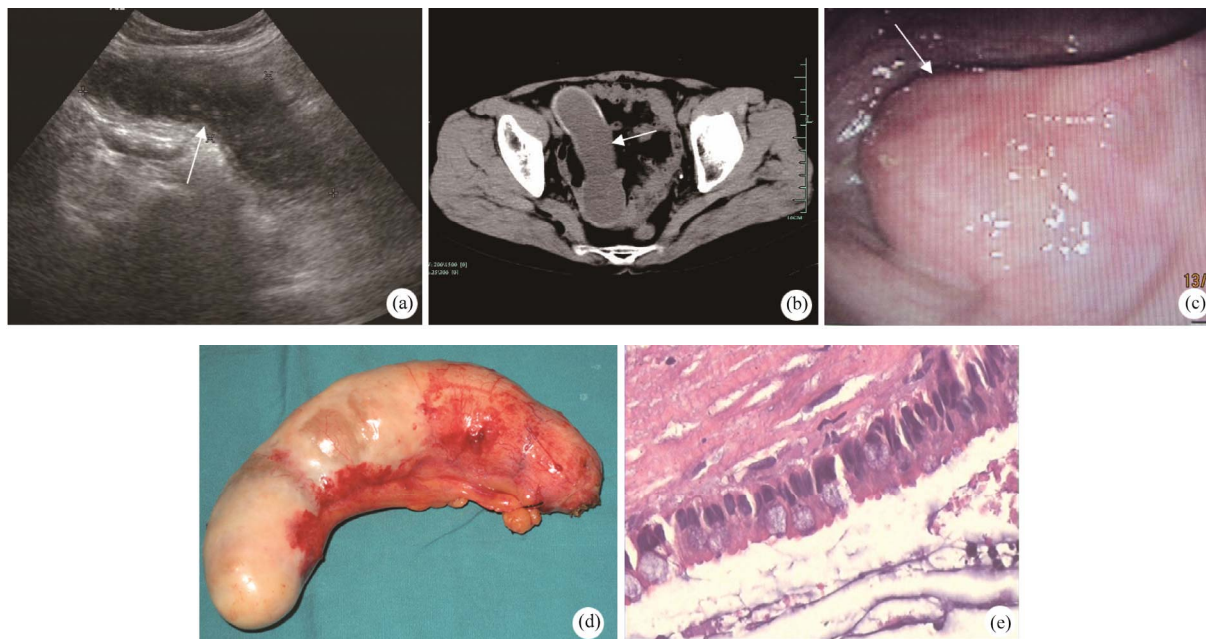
A cord-like cystic mass in right abdominal cavity, primitive impression of gastrointestinal tumor, was detected by ultrasound examination (a); and CT scan demonstrated that a cystic occupation in right pelvic cavity (b); and Exophytic tumor at cecum was found by fibrocolonoscopy (c); A sausage-like tumor with size of 15 cm × 8 cm × 5 cm was found at right abdominal cavity (d); The postoperative diagnosis was appendiceal mucocoele with granulomatous tissue at wall (e)
